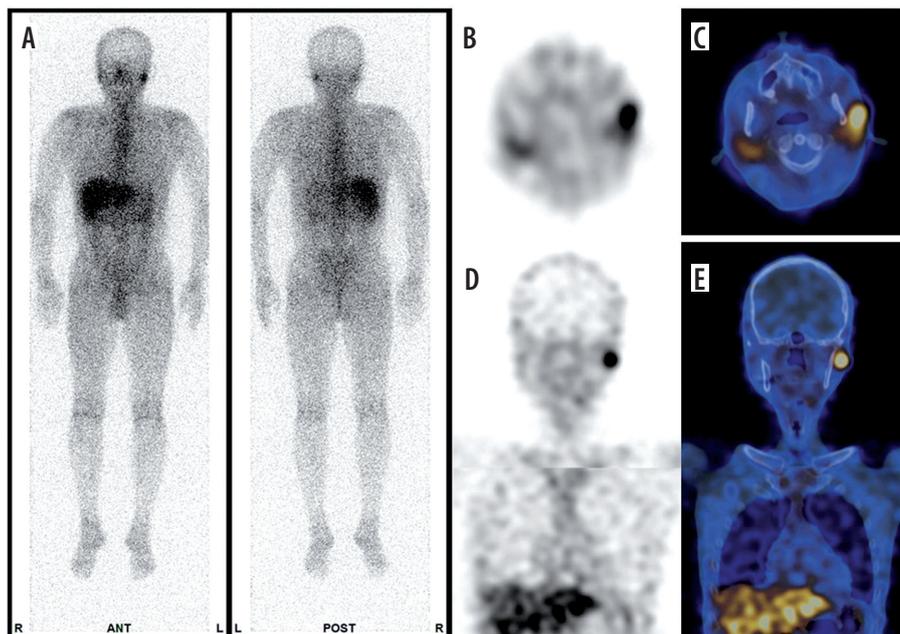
Malignant lymphoma of the left side of the neck in a 54-year-old male. A) planar, B) transaxial single-photon emission tomography (SPECT) and C) single-photon emission-computed tomography (SPECT-CT), D) coronal SPECT and E) SPECT-CT show increased uptake
